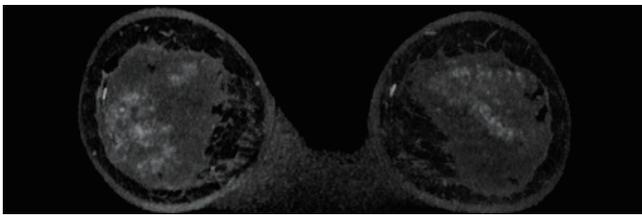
Stippled lesion Two stippled enhancements present in left breast, with diameters less than 5mm; their margin and internal enhancement are non-specific. Stippled enhancement is detected during the arterial phase, with poorly-defined margin. The scope of enhancement becomes slightly larger in the delayed phase, with slightly irregular margin. BI-RADS-MRI category 3 is considered. Pathology: Fiber adenosis. Centrifugal enhancement. B770501.
